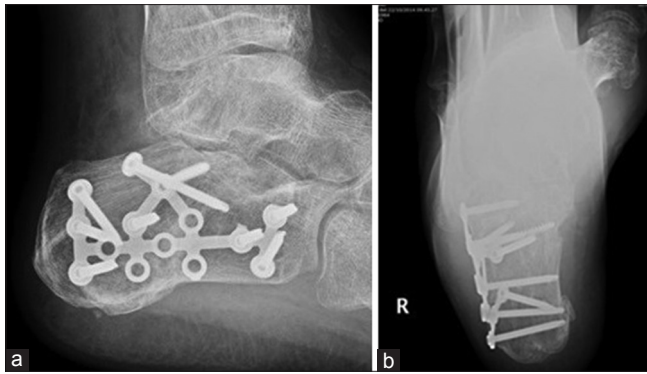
Same case. Follow-up radiographs anterior-posterior (a) and lateral (b) at 12 months. CERAMENT™ | BONE VOID FILLER has been completely resorbed
